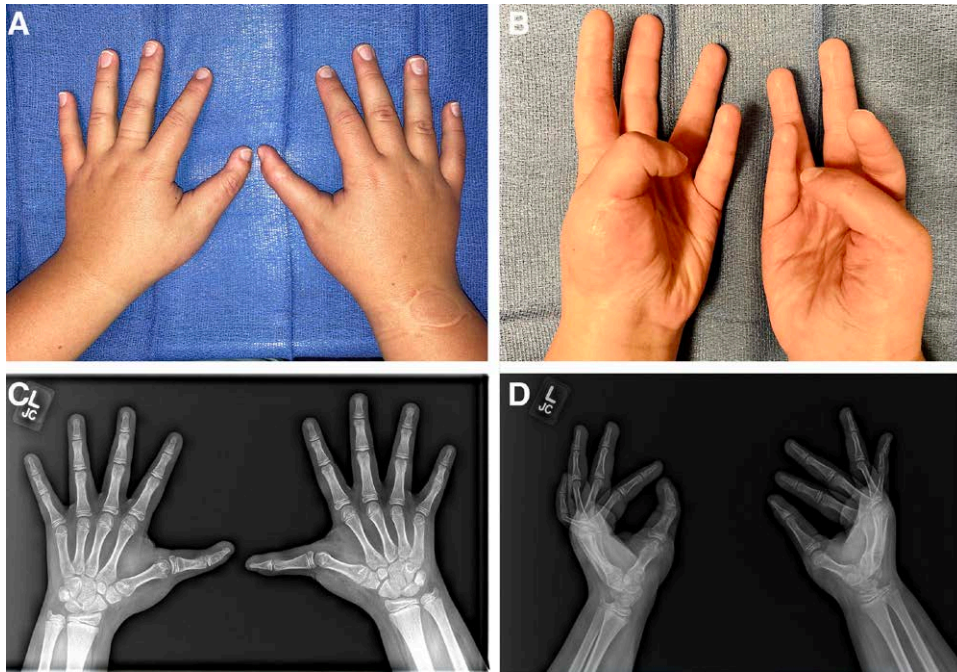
Postoperative images after surgical reconstruction for twin B triphalangeal thumbs at age 12. A, Dorsal postoperative view. B, Volar postoperative view demonstrating opposition. C, Anteroposterior postoperative radiograph. D, Oblique postoperative radiograph.
